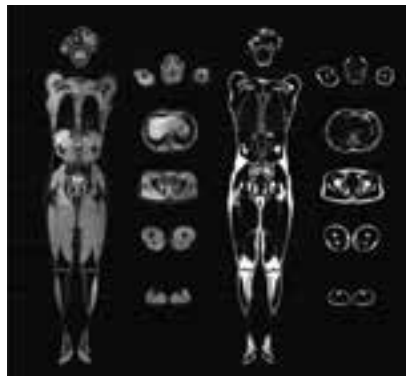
A paired magnetic resonance image where the left shows all the water within a whole body and the right shows all the fat.
